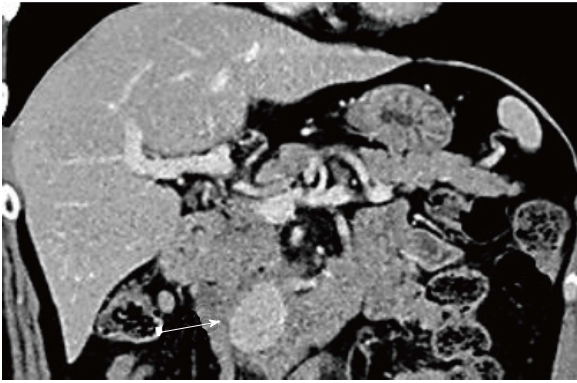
Abdominal dynamic contrast-enhanced computed tomography showed a 27-mm diameter tumor in the pancreatic uncus, which was well defined and enhanced from the arterial phase, exhibiting the greatest enhancement in the arterial phase. White arrow indicates the tumor.
